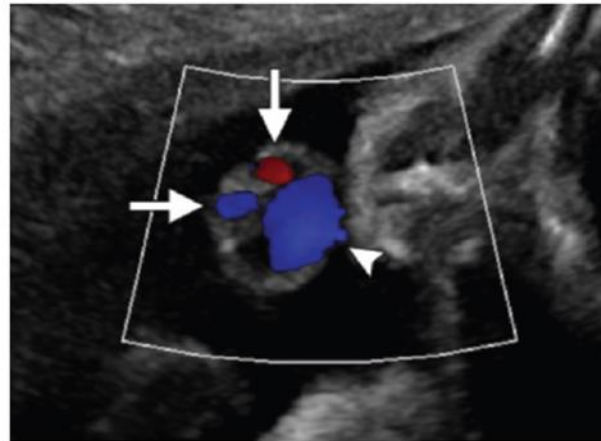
NORMAL PHYSIOLOGY OF UMBILICAL CORD IN ULTRASOUND⁸
